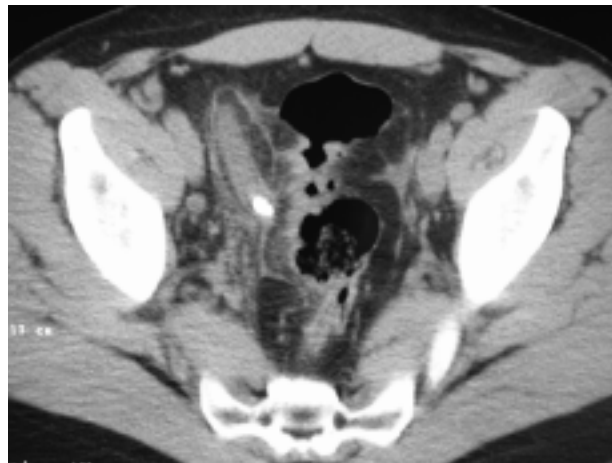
Spiral abdominal CT: demonstration of appendiceal enlargement with intraluminal calcified fecalith. Diagnosis: acute gangrenous appendicitis
